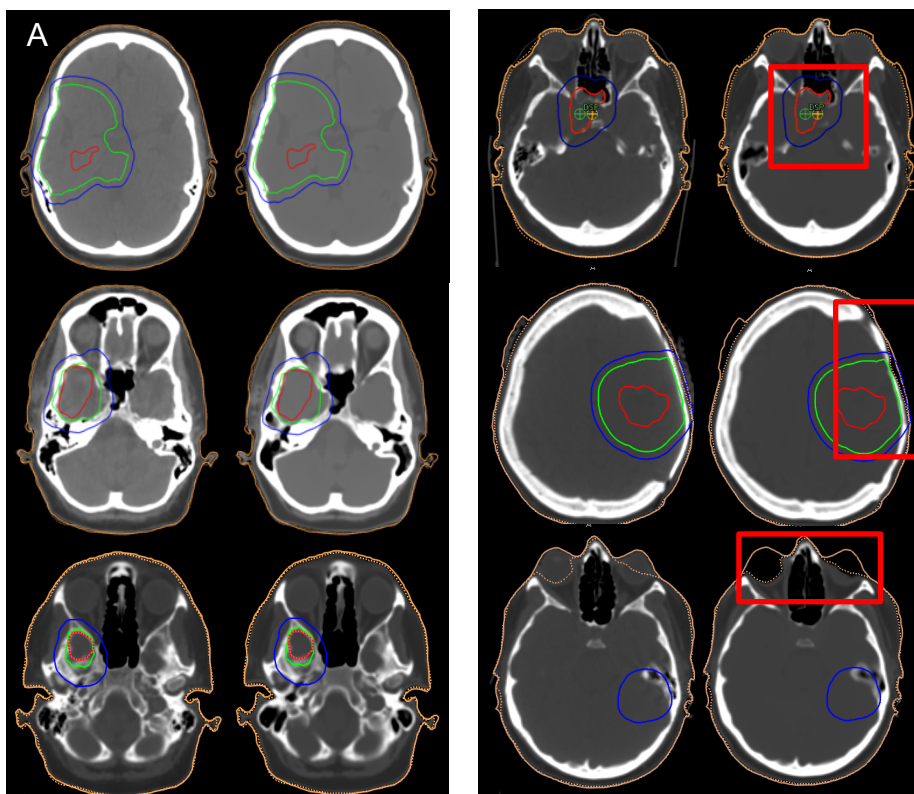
(A) Axial slices of CT (left) and sCT (right). Based on expert visual assessment, sCT images demonstrate reliable anatomical detail comparable to conventional CT scans. (B) Axial slices from three patients demonstrating dosimetric errors due to gross sCT anatomical failures, resulting in MRCAT images that are unacceptable for clinical use, CT (left) and sCT (right). The top and middle images show sCT errors in the PTV (bone), while the bottom image shows an sCT error in the OAR (orbits and lens). The structure contours are shown as PTV (blue) CTV (green), and GTV (red).
